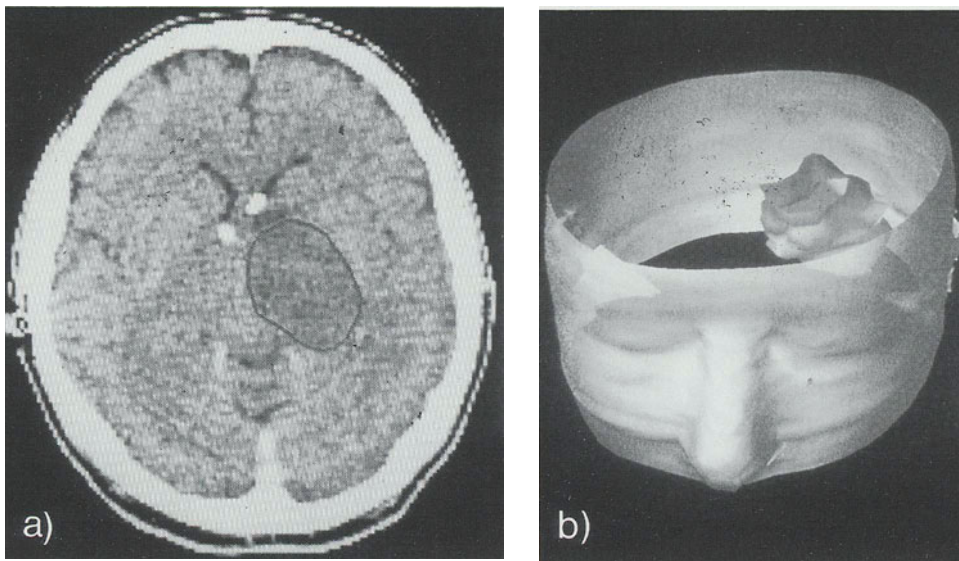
Manual segmentation of a brain tumor in a CT-image (Fig. 3a) and anatomic modelling of the target volume and the head surface (Fig. 3b).
